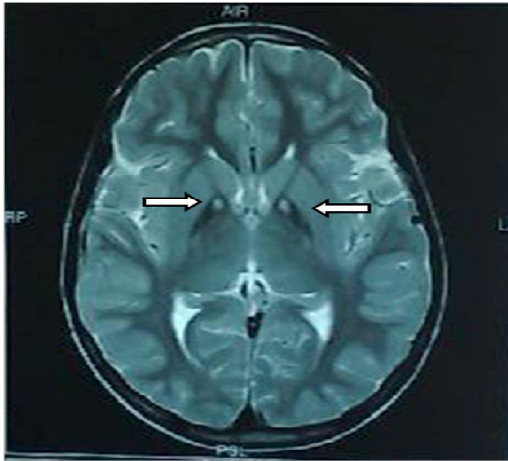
“Eye of tiger” appearance in T2W image of MRI Brain.
